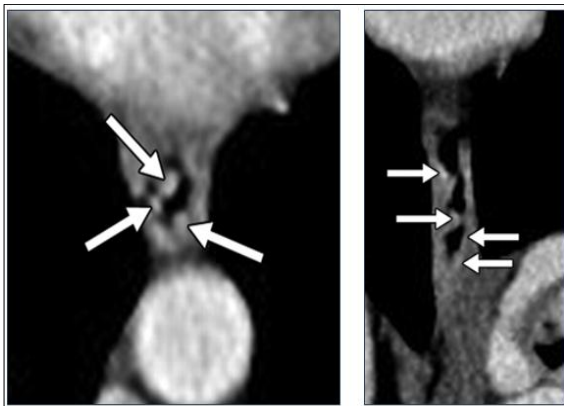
27-year-old woman with Liver left lobe hypertrophy and portal hypertension showing grade 1 esophageal varices. Portal venous phase CT images in axial and coronal plane show multiple enhancing columns
